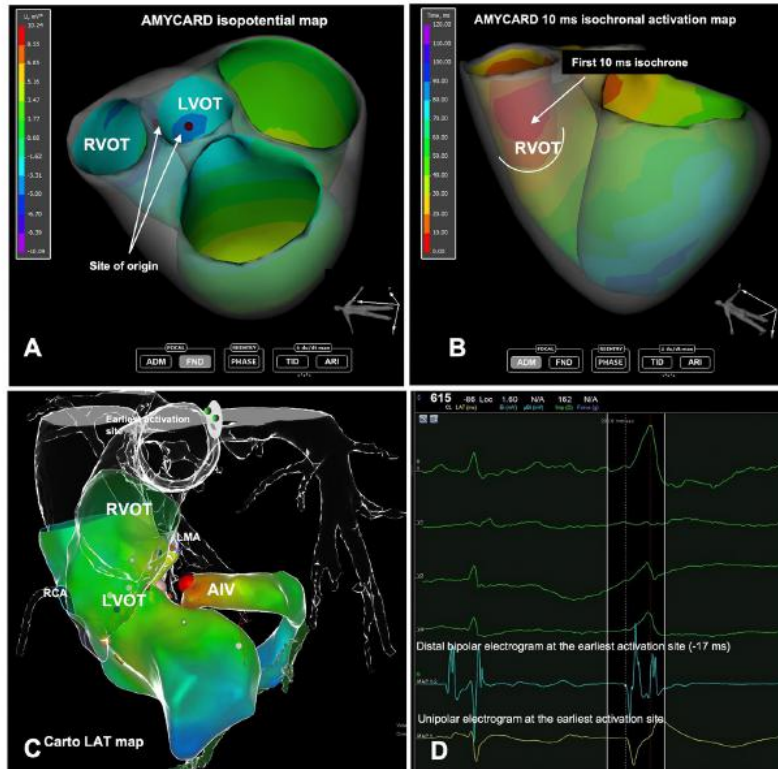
Representative case of a patient with PVCs from the LV summit. Panel A. ECGI isopotential map suggesting an activation simultaneous in the RVOT and LCC. Panel B. ECGI isochronal map showing a short activation duration in the RVOT, with a wide first 10 ms isochrone and 3 isochrones across the RVOT. Panel C. Carto activation map with the RVOT map displayed in transparent mode and RF applications in the RVOT, LVOT and AIV. Transparent CT scan superimposed on Carto map. Panel D. Intracardiac electrograms at the earliest activation site inside the AIV. AIV: anterior interventricular vein; LAT: local activation time; LMA: left main artery; LVOT: left ventricular outflow tract; RCA: right coronary artery; RVOT: right ventricular outflow tract.
